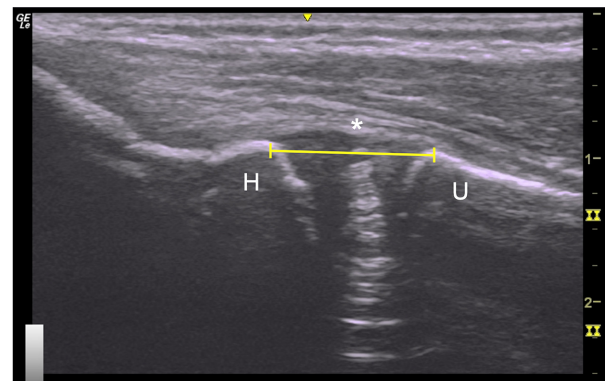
Sample ultrasound image to measure medial ulnohumeral joint distance. A measurement bar was superimposed to demonstrate the location of measurements taken on the ultrasound device. Measurements were taken at the apex of the ossified portion of the humeral and ulnar epiphysis. When the ossified portion of the epiphysis was less defined, but the edge of the cartilaginous epiphysis was more clearly defined, then the apices of the humeral and ulnar epiphyses were used for a given subject. A single method was used per subject for consistency within that subject's measurements to measure the change in medial ulnohumeral joint distance. The asterisk indicates longitudinal fibers of the UCL, and the yellow bar indicates the ulnohumeral joint distance. H, humerus; U, ulna; UCL, ulnar collateral ligament.
